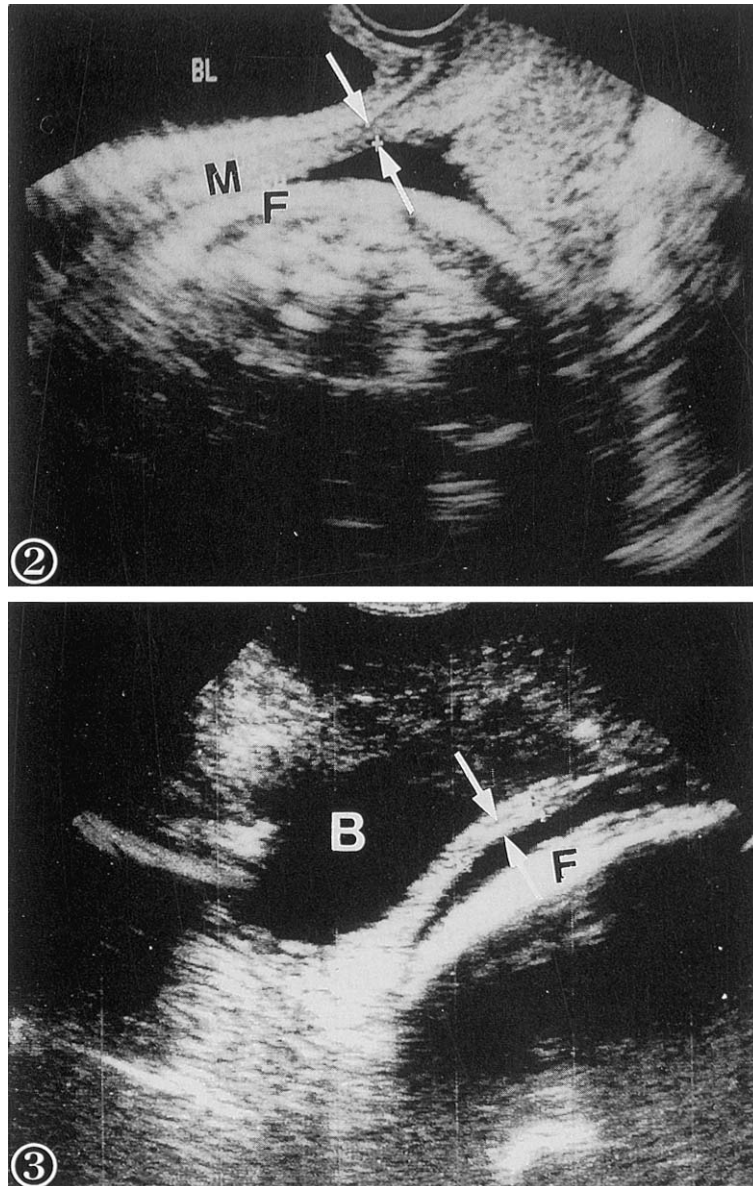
Sonogram of a patient with previous cesarean section with good healing at 29 weeks. The myometrium shows thickness of 4 mm between the arrows. BL, bladder; M, myometrium; F, fetus.
